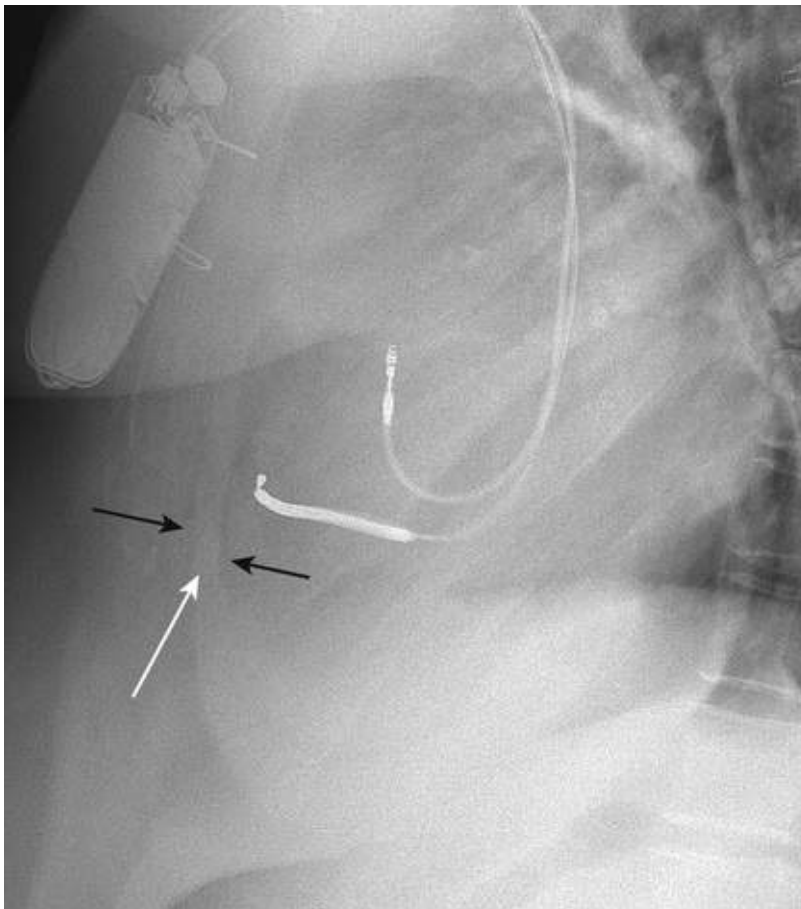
“Sandwich sign” of pericardial effusion. Coned-down lateral chest radiograph shows two dark bands of radiolucency (*black arrows*), separated by a band of radiodensity (*white arrow*), resulting from separation of the pericardial and epicardial fat pads by a moderate-sized pericardial effusion. The white band wraps around the inferior border of the heart, since the fluid tends to accumulate when standing.
